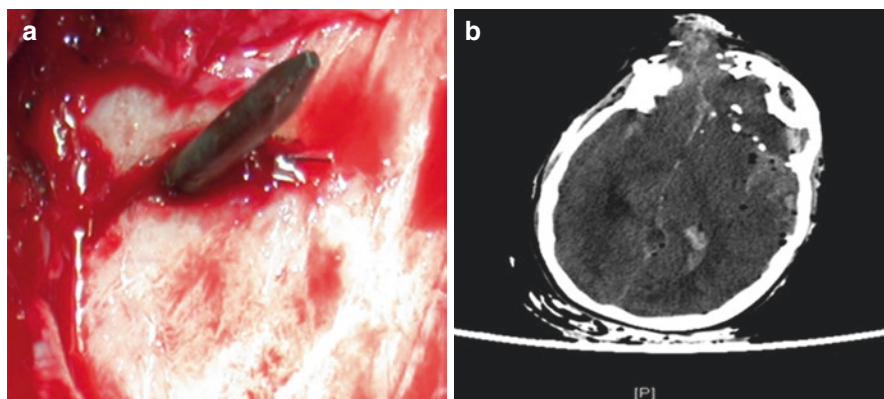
Penetrating skull injuries following bombing attack. Nail in the skull (a). CT scan of head with penetrating injury caused by flying missile following blast injury (b)
